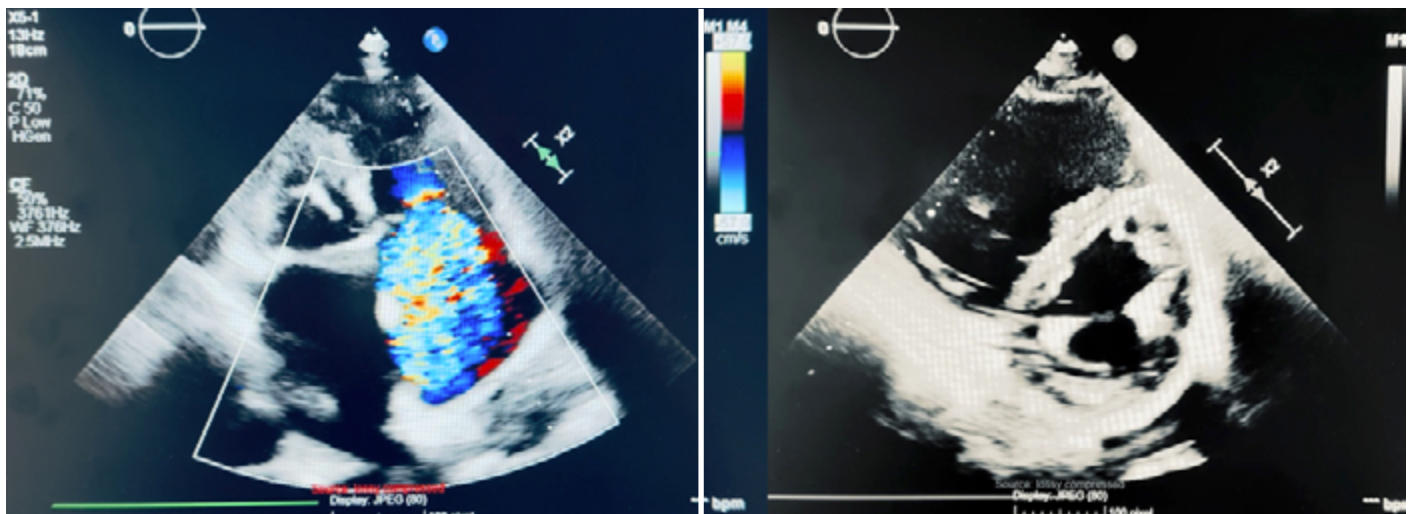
Transthoracic echocardiography. (Left) Apical four-chamber view with color Doppler demonstrating severe tricuspid regurgitation with a broad, high-velocity regurgitant jet. (Right) Corresponding grayscale image showing significant dilatation of the right ventricle and a D-shaped left ventricle, corresponding to increased right heart pressures.
